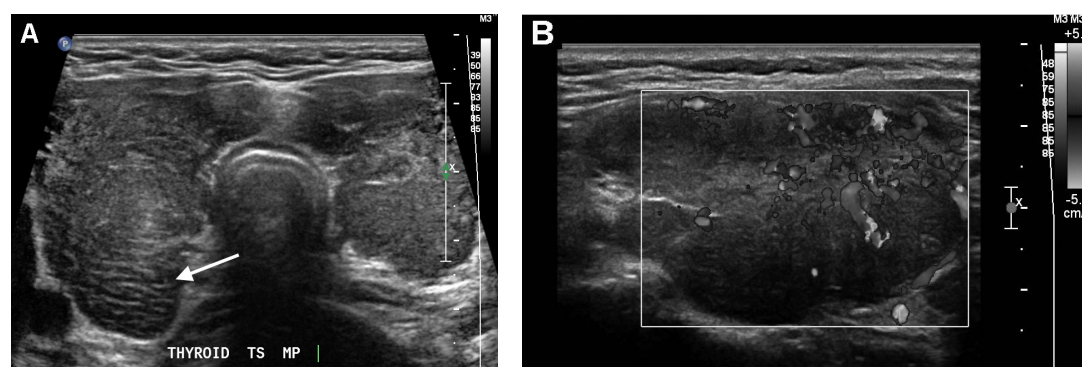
A) is a transverse greyscale image of the thyroid gland from a 44-year-old woman referred for a diffuse goitre. There was no known history of HT. The thyroid gland shows diffuse asymmetrical enlargement (right lobe more than left). There are features of diffuse HT in the background parenchyma—heterogeneous echotexture with micronodule formation (arrow) and geographic areas of hypoechogenicity (comparable to that of the strap muscles). However, no discrete focal nodule is otherwise seen in this cross section. B) is a colour Doppler image of the left thyroid lobe demonstrating increased parenchymal vascularity, another feature of diffuse HT.
